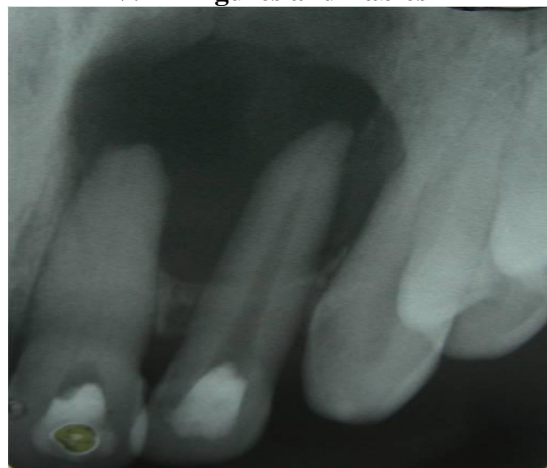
Intra-oral Periapical radiograph of 21 22
